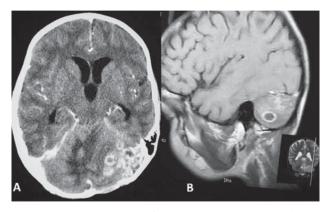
A) CT scan showing mass in posterior fossa, B) MRI showing the mass in the cerebellum
